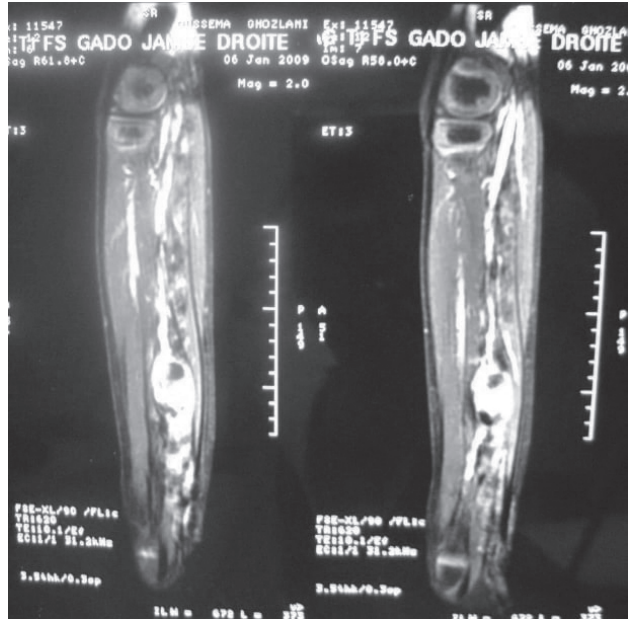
Peroneal artery pseudoaneurysm MRI aspect
